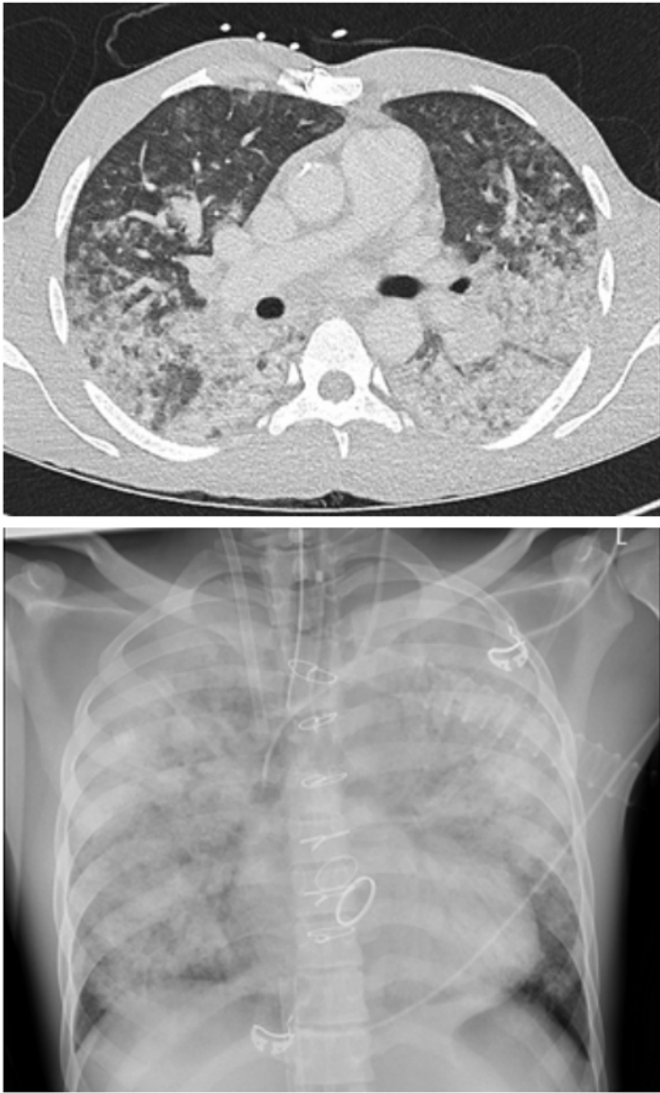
CT and Chest-X ray with bilateral diffuse alveolar opacification.
